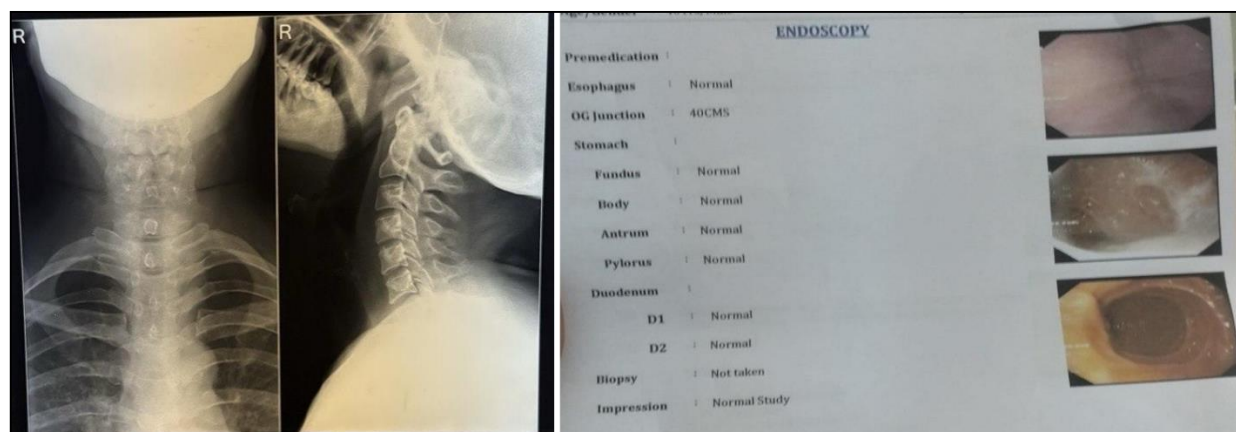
Postoperative anteroposterior and lateral neck radiographs showing no retained foreign body, with follow-up upper GI endoscopy demonstrating normal findings after hypopharyngoscopic removal of the safety pin.
